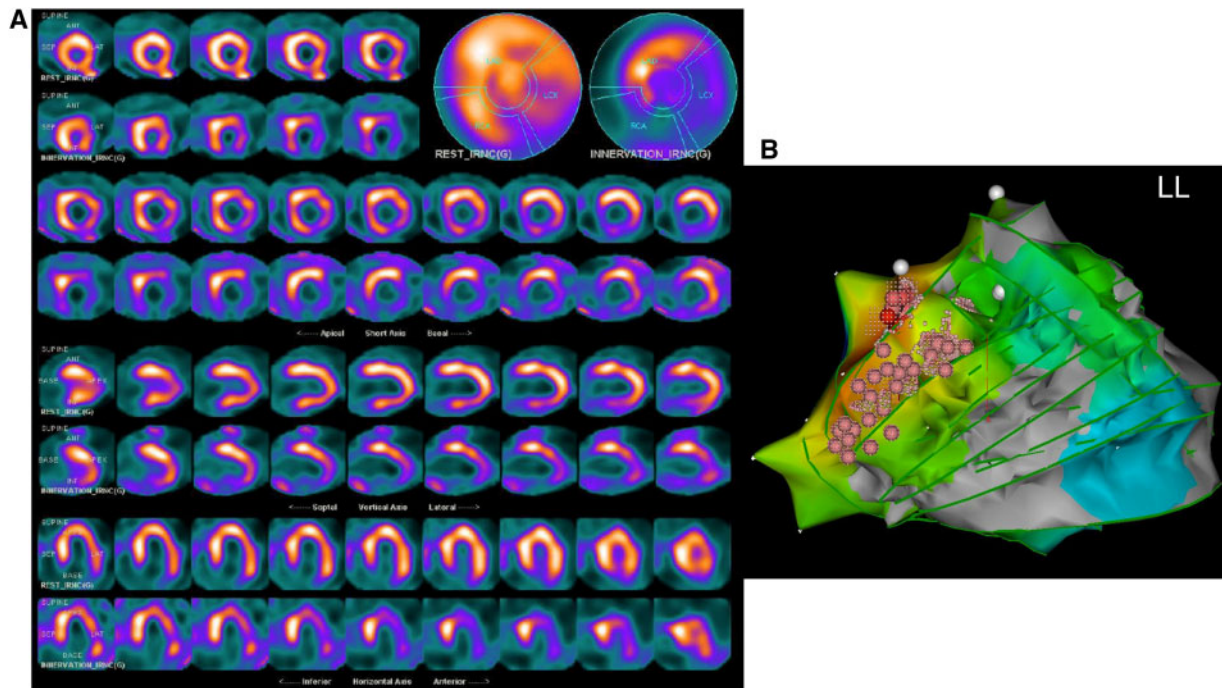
A 62-year-old woman with idiopathic cardiomyopathy and a history of ventricular arrhythmias presenting recurrent episodes of ventricular tachycardia. (A) The scintigraphic perfusion images show homogeneous perfusion in the whole left ventricle, with the exception of a minimum reduction of perfusion in the proximal portion of the inferior wall (SRS 1, not significant). The innervation images (lower rows) reveal an extensive area of denervation involving the lateral and inferior walls (SS-MIBG 17) with a clear innervation/perfusion mismatch. (B) At EP study located the sites of origin of the arrhythmia at the level of the inferior and inferolateral LV walls.
